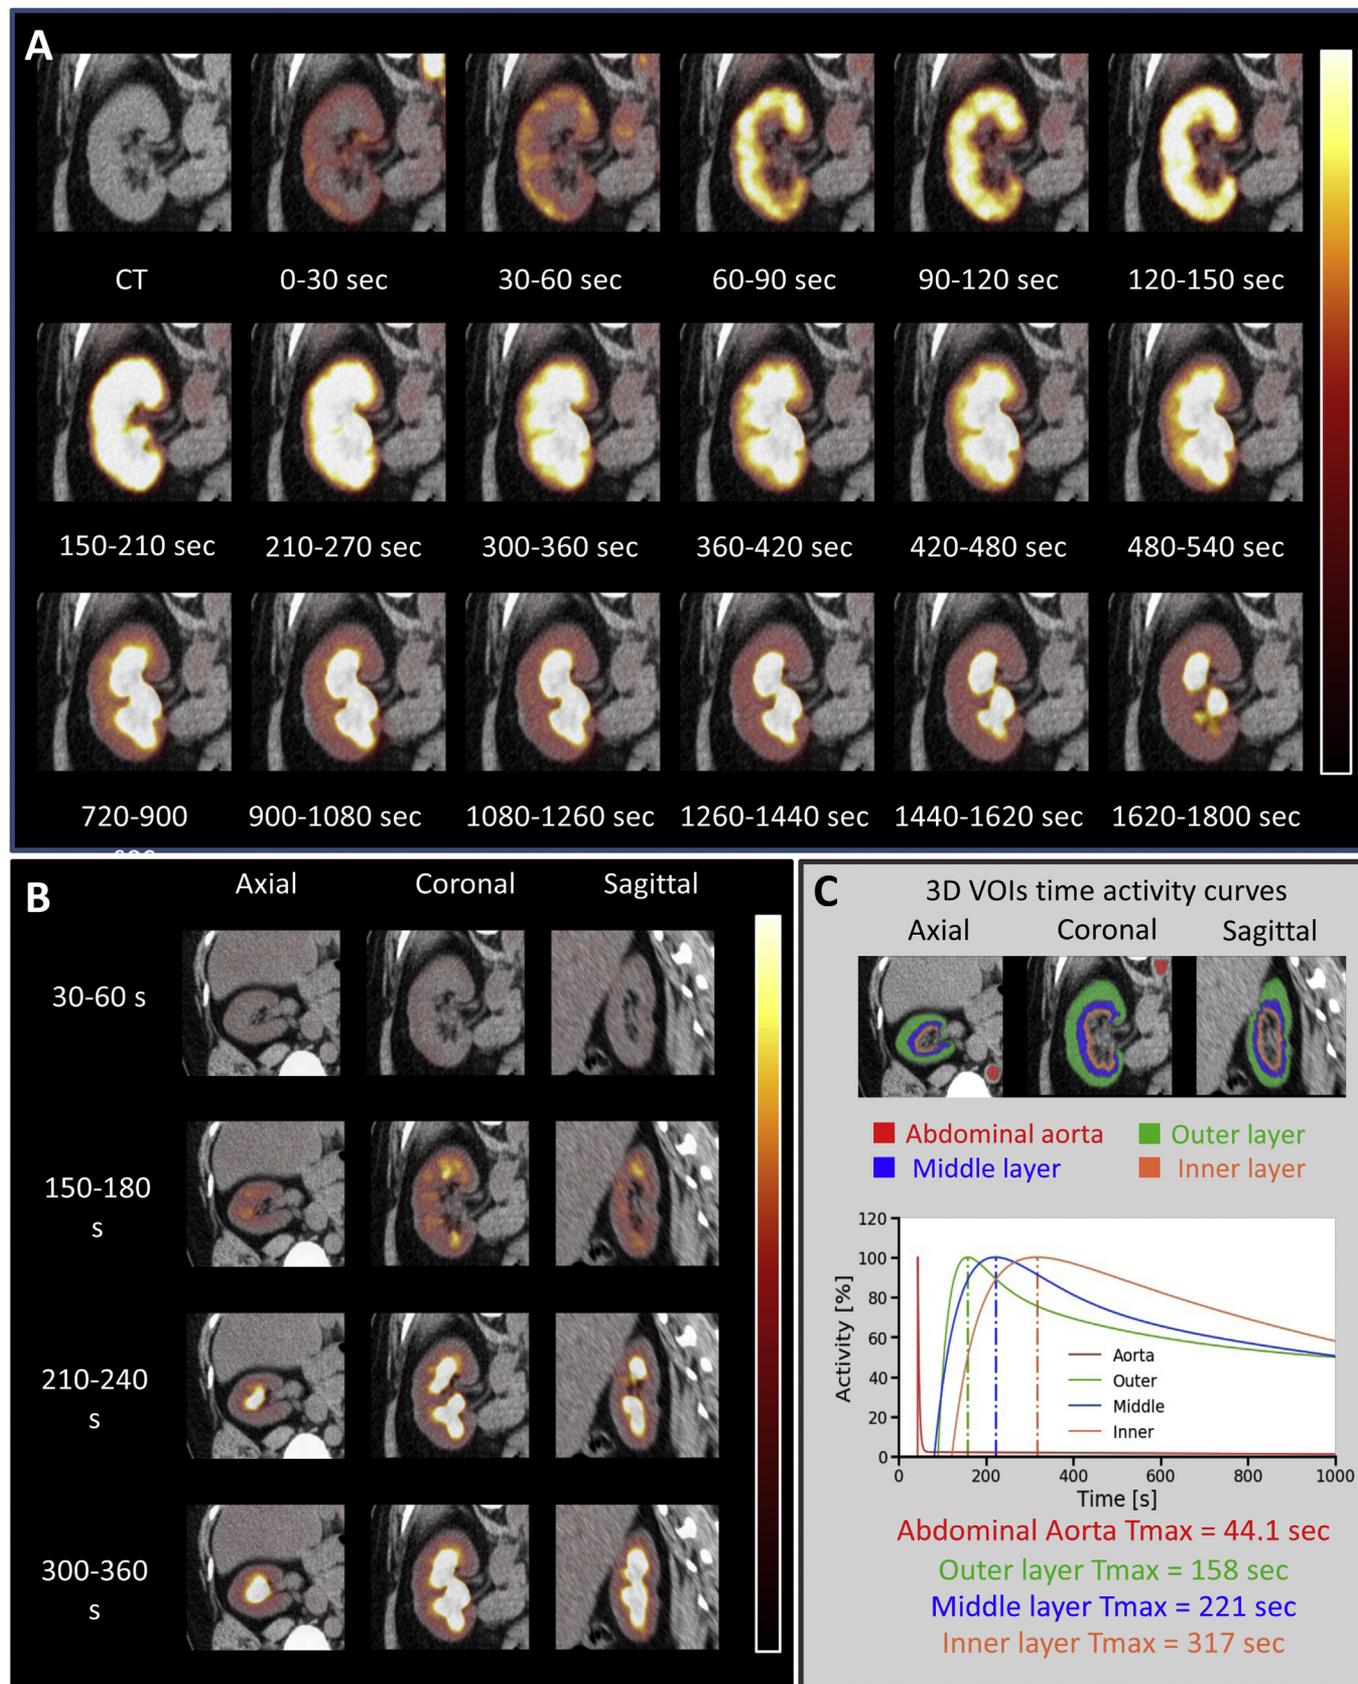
[^{18}F]FDS PET/CT imaging in volunteer (right kidney). As indicated by (A) coronal and (B) axial, coronal, and sagittal views, [^{18}F]FDS first accumulated in the renal cortex and was then excreted via the pelvis. (C) Volumes of Interest (VOIs) included the outer layer (i.e., cortex, green), the middle (blue) and inner portion (orange), i.e., the medulla. Respective time-activity curves showed a rapid transit through the kidneys, as indicated by the different layers. Reproduced from Werner et al., Novel Functional Renal PET Imaging With ^{18}F -FDS in Human Subjects. *Clin Nucl Med.* 2019;44(5):410-1 (10). Published by Wolters Kluwer Health, Inc. Licensed under CC BY 4.0 <https://creativecommons.org/licenses/by/4.0/>.
